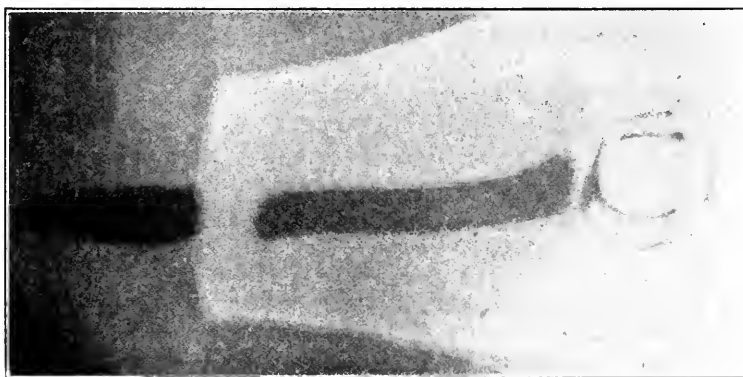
<sup>1</sup>—Annular stricture at peno-scrotal angle. Note lightness of shadow at point of stricture dependent upon small amount of fluid in the constricted area, and dilatation of proximal portion of urethra. X-ray of stricture with argyrol in urethra.
